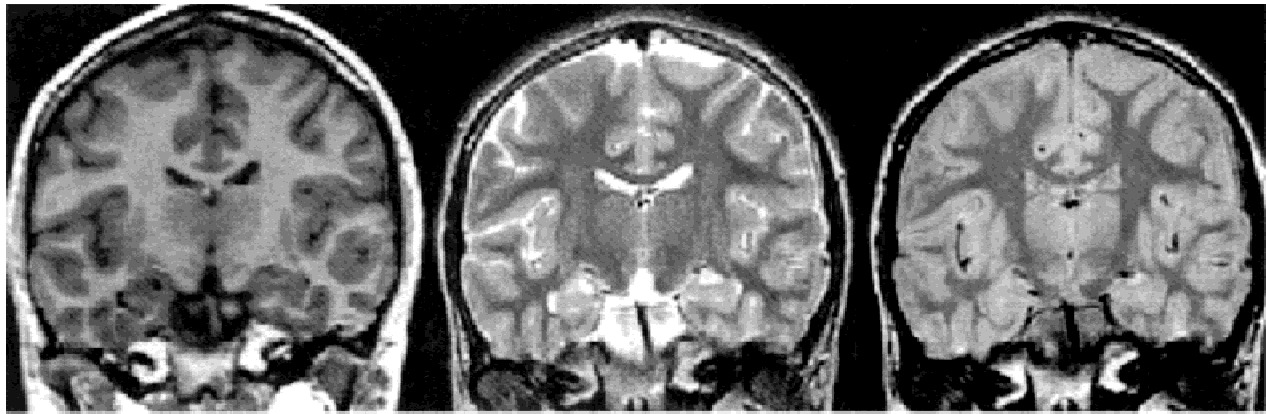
Representative images from the standard 3-D and fast spin-echo protocols. Left: 3-D gradient-echo (SPGR) T1-weighted series with TR = 24 ms, TE = 5 ms, NEX = 2, flip angle = 45°, field of view of 24 cm, section thickness of 1.2 mm, no gaps. Middle: coronal section, TR = 3000 ms, TE = 17 ms, ET = 4; Right: spatially registered coronal section TR = 3800 ms, TE = 102 ms, ET = 8; for both sets field of view was 24 cm, section thickness 4 mm, no gaps (interleaved).
